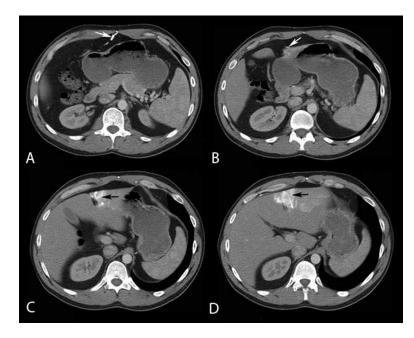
Axial, contrast-enhanced portal venous phase CT images from the same study as Fig 3, obtained more inferiorly. There is recanalization of the paraumbilical vein (white arrows, A, B), draining to the anterior liver, resulting in hyperenhancement of segment IV of the left lobe of the liver, correlating with the region of hypoattenuation seen on the prior CT (black arrows, C, D).
